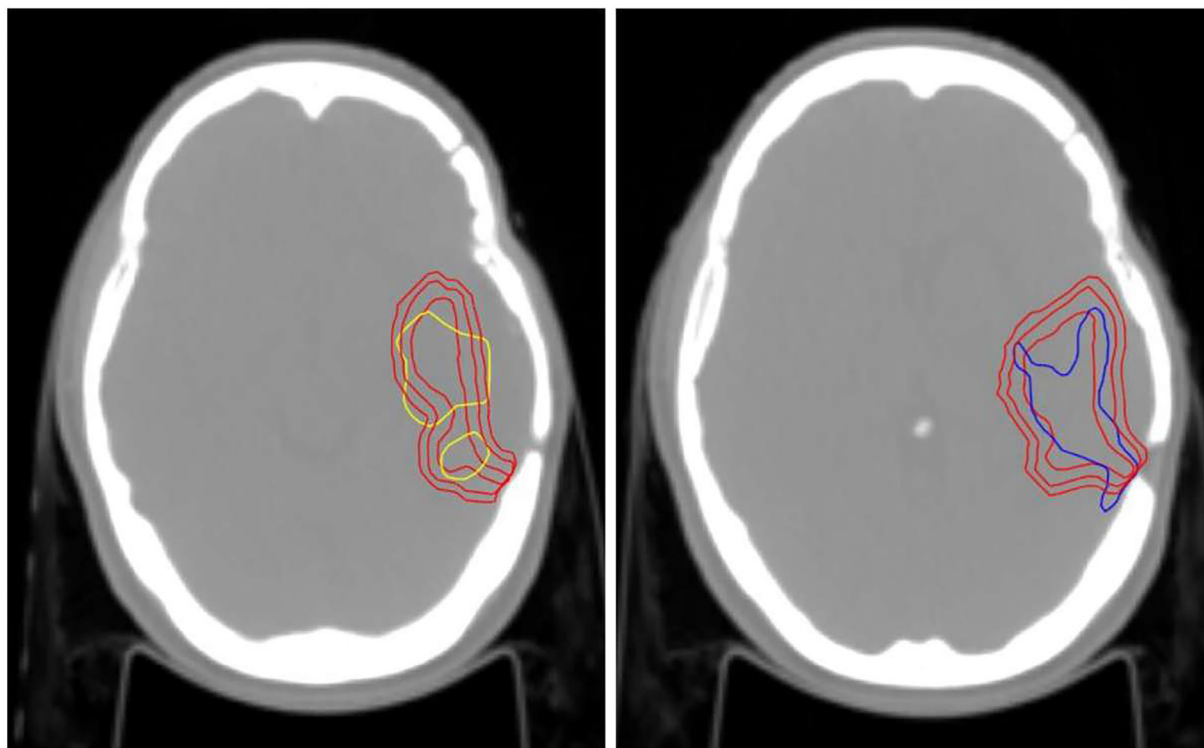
Relationship of gross tumor volumes delineated by ^{68}Ga -prostate-specific membrane antigen on the left (in yellow) and ^{11}C -methionine positron emission tomography on the right (in blue) with magnetic resonance imaging (MRI) target contours, as seen in a case of recurrent glioblastoma. The red contours represent gross tumor volume_{MRI} (the smallest and innermost red contour), CTV_{MRI_3 mm} (the intermediate red), and CTV_{MRI_5 mm} (the outermost red). The 2 images represent different slices, independently chosen to highlight the divergence of each positron emission tomography contour with MRI. CTV = clinical target volume.
